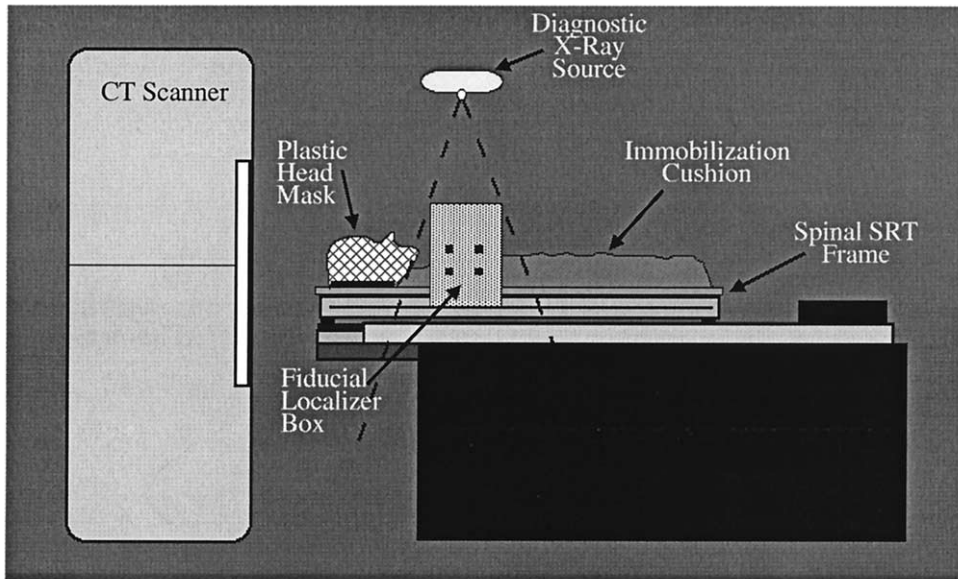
SSRT imaging before treatment planning. A CT scan provides anatomic information for treatment planning and target selection, whereas concurrent biplanar radiographs are used to determine implant coordinates. Immobilization devices may be used to restrict patient motion.
